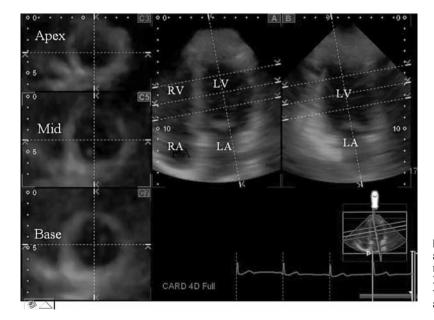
Example of images generated from a 3-dimensional data set. The multiplanar reconstruction images correspond to the apical 2-chamber (right panel: B) and 4-chamber views (central panel: A) and 3 short-axis views at different levels (left panel: C3, C5, and C7).
